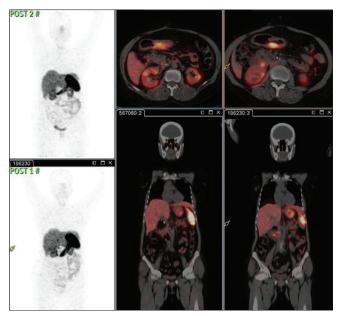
Comparison of 68Ga-DOTATE positron emission tomography-computed tomography in case 2
